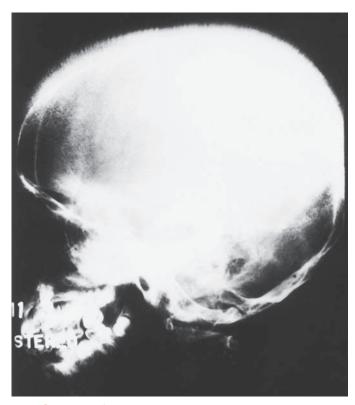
Increased erythropoiesis in the bone marrow of patients with β-thalassemia major expands the marrow cavity producing the typical "hair-on-end" appearance as seen on this radiograph of the skull of a boy with β-thalassemia.
